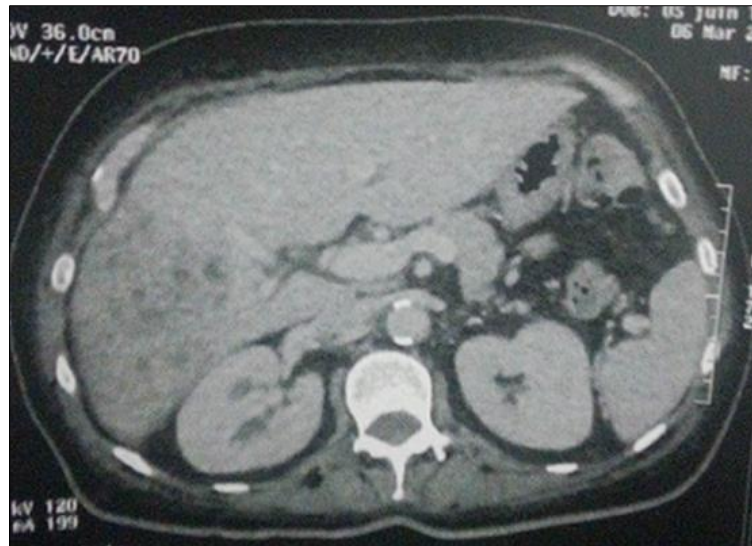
Abdominal computed tomography scan showing a low density lesion in the liver suggestive of liver abscess (red arrow)
